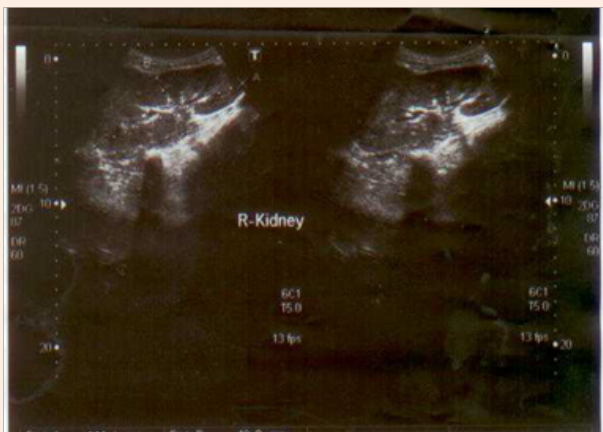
Ultrasound showing.
